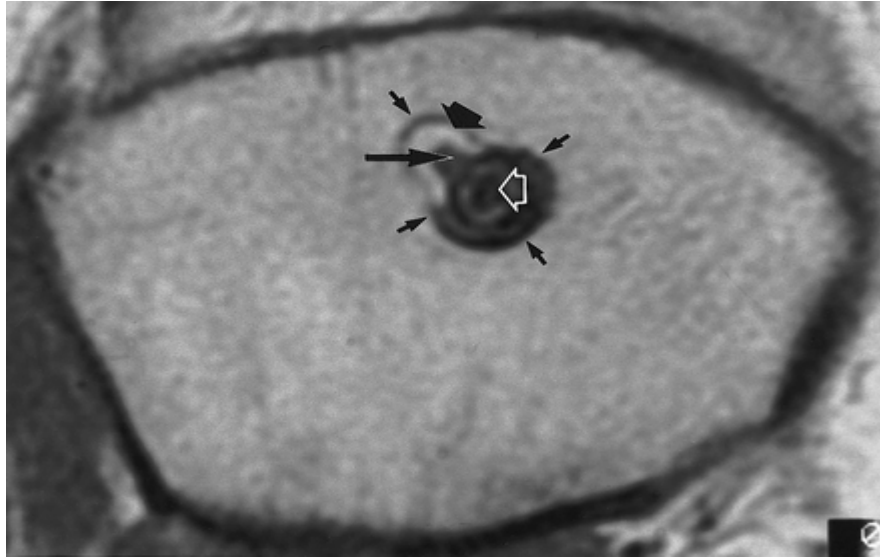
This MR image shows a surgical graft after the screw has completely degraded. The tunnel where the screw used to be implanted is indicated by the small arrows. New tissue that formed around the bone plug (open arrow) was determined to be a fibrous tissue (long skinny arrow) with fatty tissue surrounding it (thick short solid arrow) (Bach, et al.).
